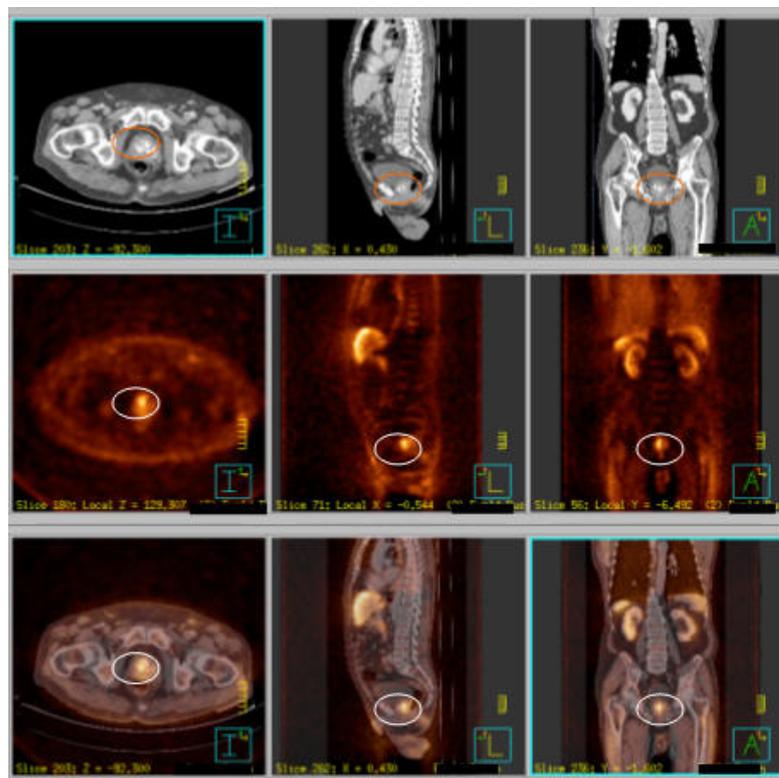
PET-CT image: The 1st row depicts the CT-, the 2nd the PET- and the 3rd the co-registered image. The high uptake of the ^{11}C -Choline tracer in cancerous tissue seen in the PET image (the glowing spot within the ellipse) can be allocated within the prostate depicted in the CT image by co-registration of the images. From Ref. [12].
